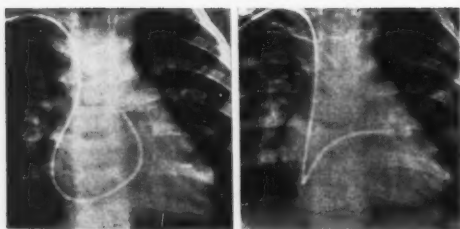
Roentgenograms (case 1) showing the positions of the cardiac catheter when the tip lay in the right ventricle (left) and the left ventricle (right). It was not possible to advance the catheter to enter a great vessel from either of these positions.
